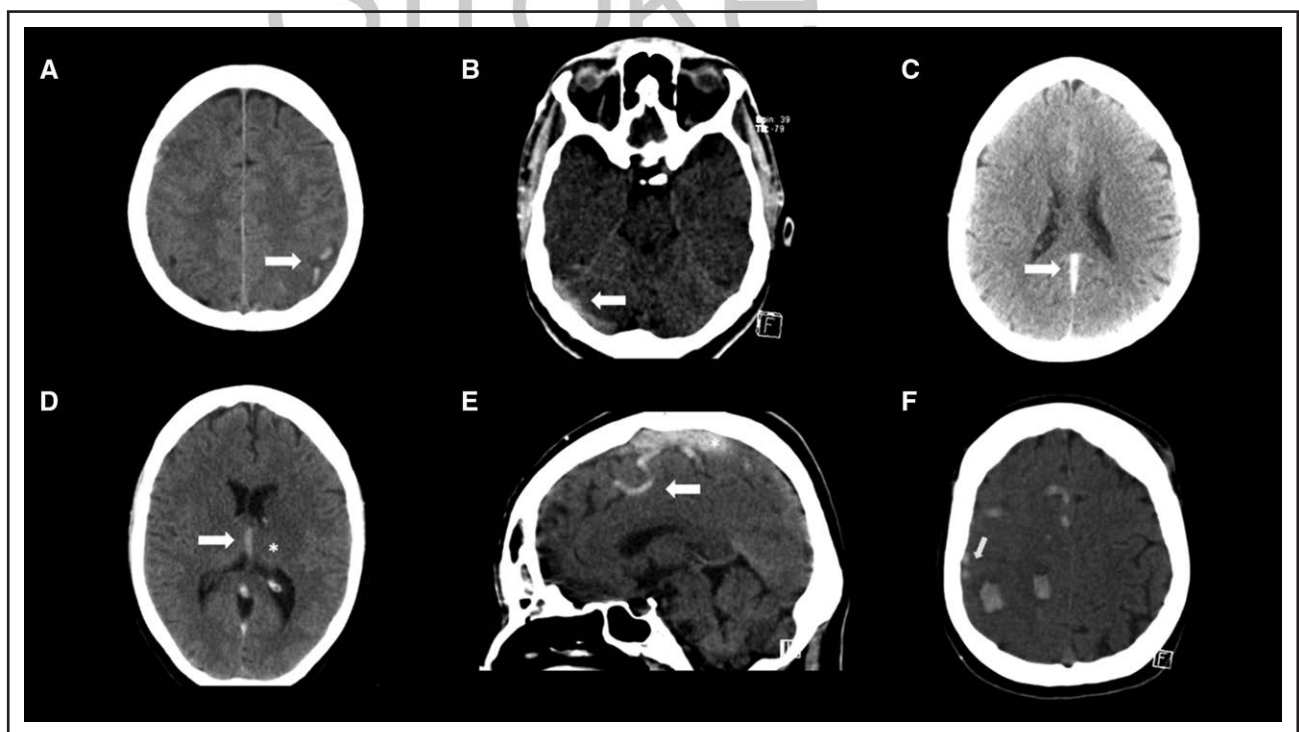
Typical findings of cerebral venous thrombosis on noncontrast computed tomography.
